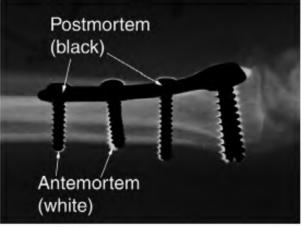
This initial superimposition revealed noticeable linear and angular differences between the antemortem and postmortem device images. This was caused by differing positions of the forearm on the film cassette between the two radiographic sessions (1994 and 2001). This is called Type II distortion.
